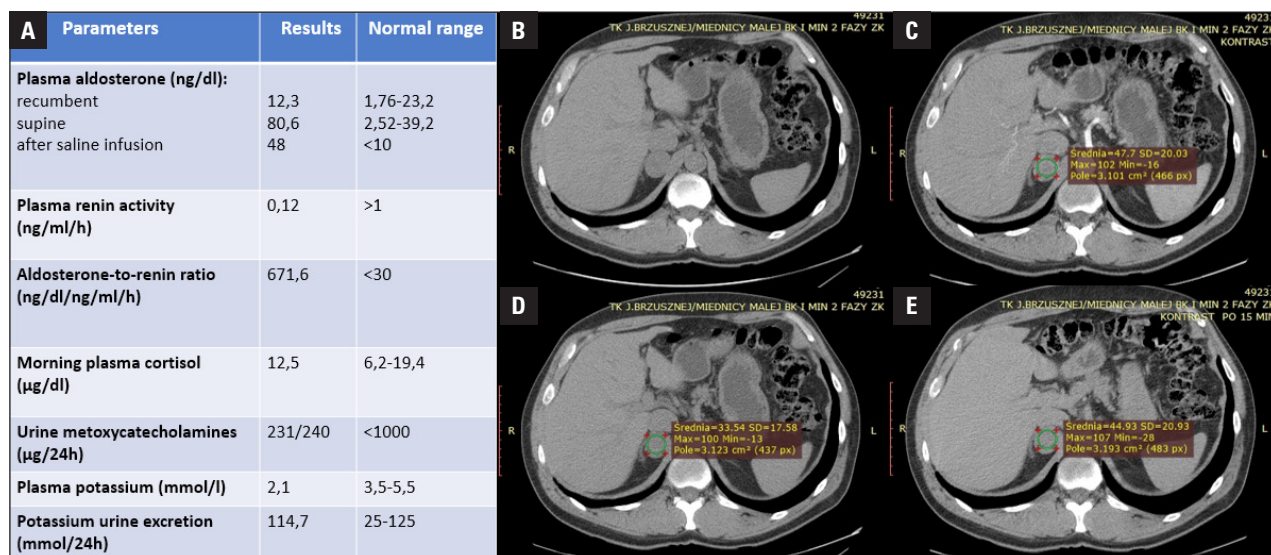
A. Hormonal test results. B. Computed tomography (CT) of the abdomen showing the tumour in the right adrenal gland. C–E. Re-evaluation of CT images showing suspicious attenuation values before, 1, and 15 minutes after contrast administration, respectively
